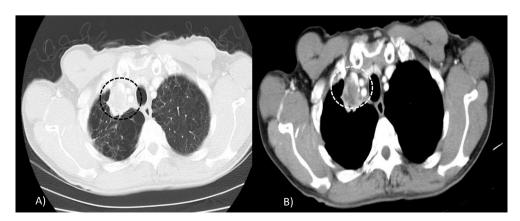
Computed tomography of the chest revealed a mass lesion adjacent to vessels in mediastinum. Tumor lesion was indicated by dotted circle. A) The introducible bronchus to mass lesion was not identified. B) Because an innominate vessel was located over the tumor, we could not find the route of percutaneous CT guided needle biopsy.
